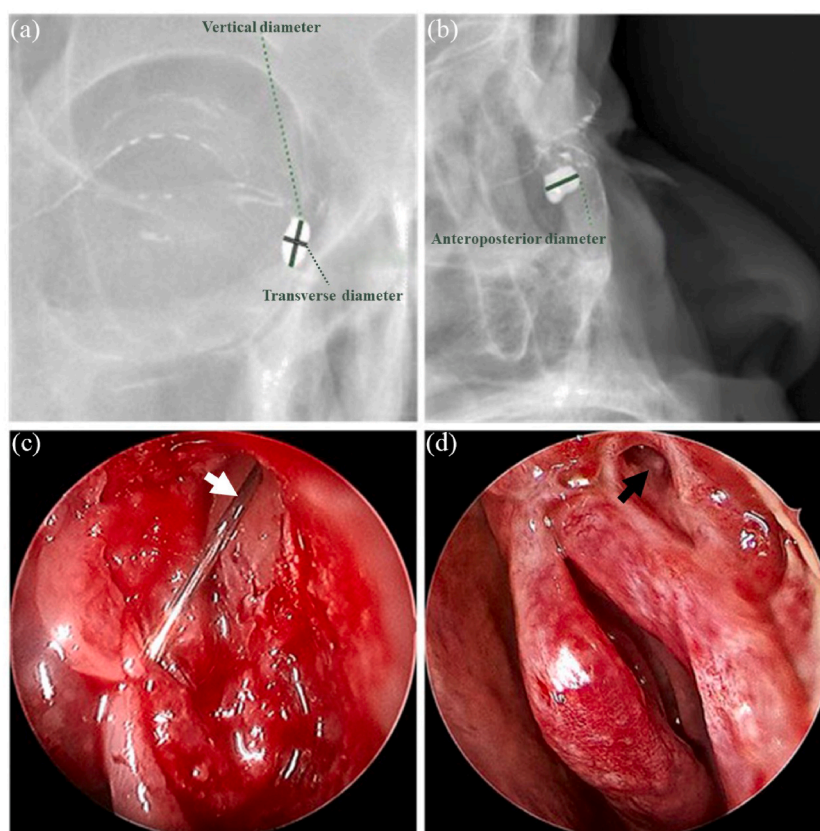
Typical image of digital radiography dacryocystography. (a) The vertical and transverse diameters of the lacrimal sac on the coronal view; (b) The anteroposterior diameter of the lacrimal sac on the sagittal view. Typical clinical photograph of the endoscopic dacryocystorhinostomy. (c) The white arrow points to the lacrimal probe through the opening of the common lacrimal duct; (d) The black arrow points to the ostium after the endoscopic dacryocystorhinostomy.
